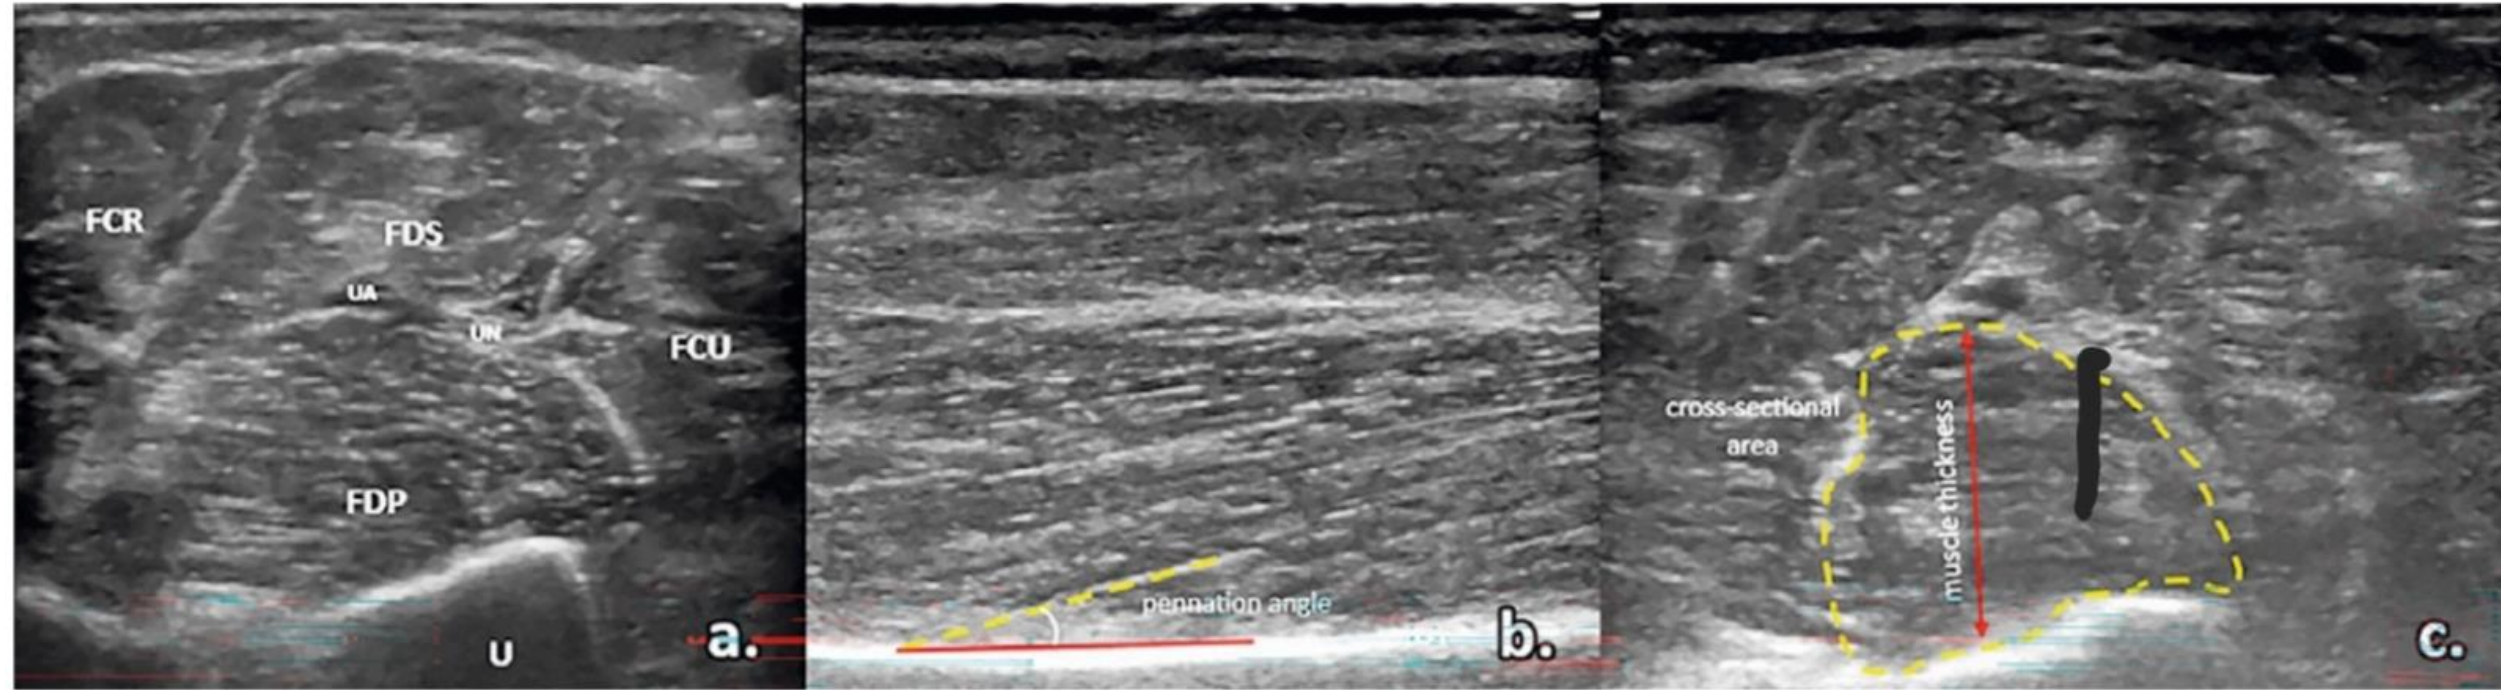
Grayscale ultrasound examination of the flexor digitorum profundus muscle (FDP) (a) transverse scan proximal third of the forearm; (b) longitudinal scan measurement of the pennation angle; (c) transverse scan measurement of cross-sectional area and muscle thickness. U, ulna; FCR, flexor carpi radialis muscle; FDS, flexor digitorum superficialis muscle; FCU, flexor carpi ulnaris muscle; UN, ulnar nerve; UA, ulnar artery.
